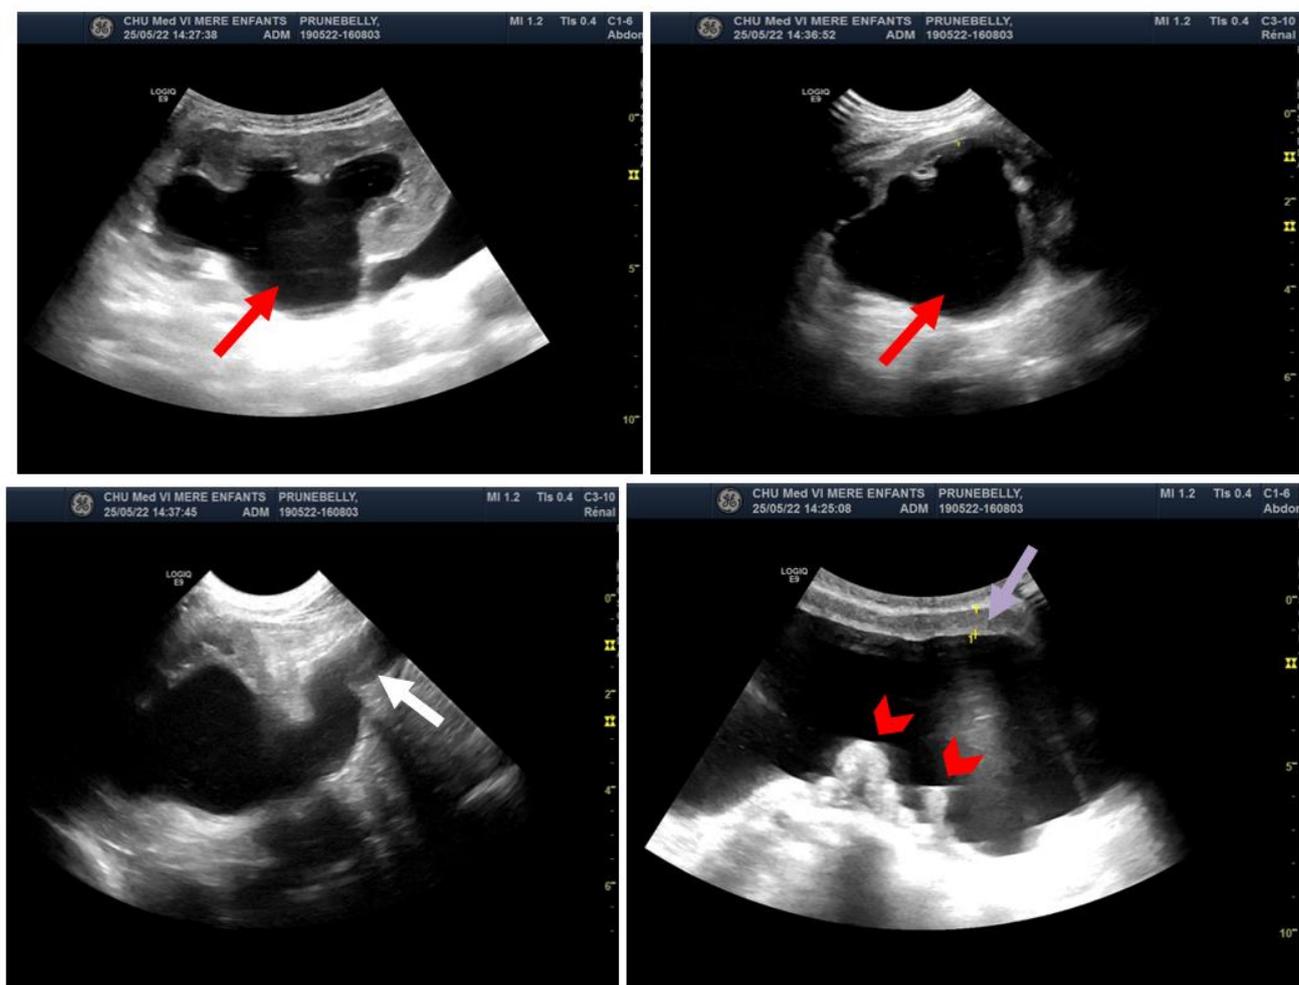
Abdominopelvic ultrasound showing major bilateral ureterohydronephrosis (red arrows), with tortuous appearance of ureters (white arrow), associated with a thickened-walled (yellow arrow) diverticular megabladder (red head arrows)
